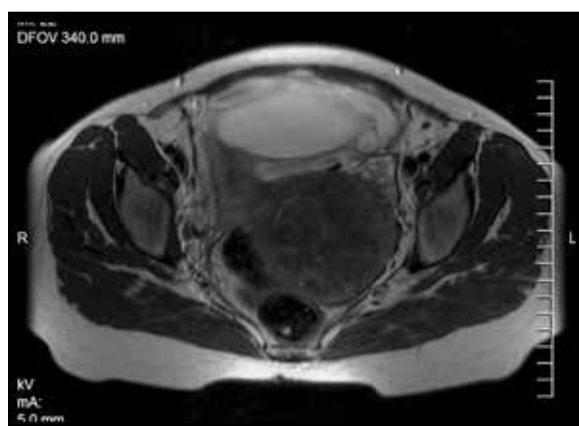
Pedunculated myoma in a pregnant patient (week 22 of gestation) displacing the rectum/sigmoid to the right and neighboring the left ovary. On ultrasound, it was not possible to differentiate between myoma and ovarian tumor.
